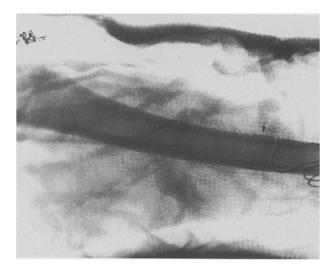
X-ray of the tibia with the glued fragment (arrow), immediately following surgery.
